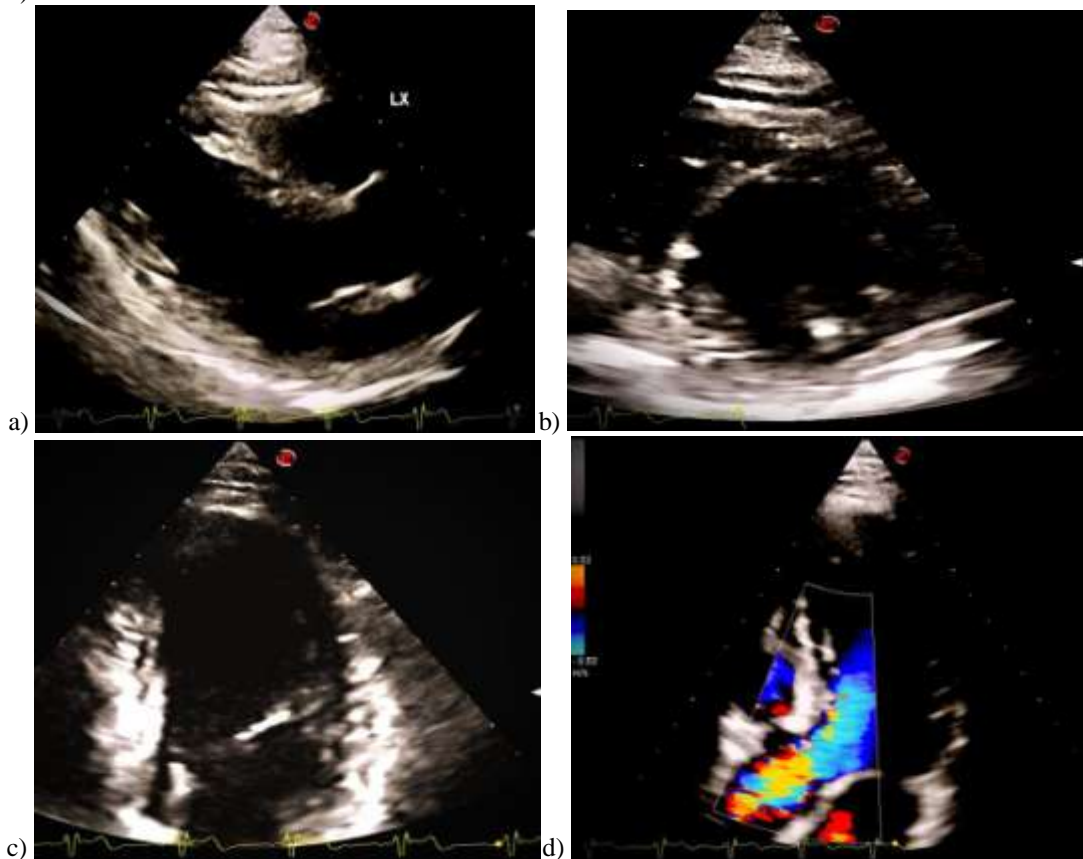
Standard 2Dimensional - Transthoracic Echocardiography was performed in (a), LX View, (b), SX View,(c), 4CH View(c) and (d)5CH View. There was presence of hypokinesia in anterior, mid septum, mid anterior septum, apical and mid anterior wall (LAD Territory).
